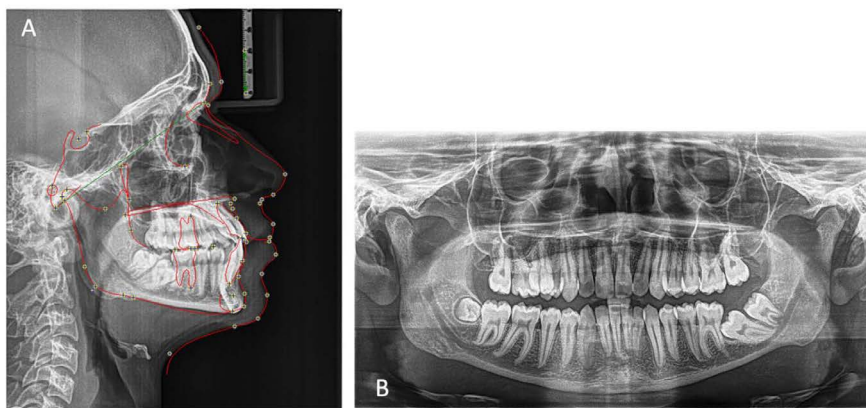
Pre-treatment radiographs: A. Lateral Cephalogram with tracing; B. Orthopantomogram
